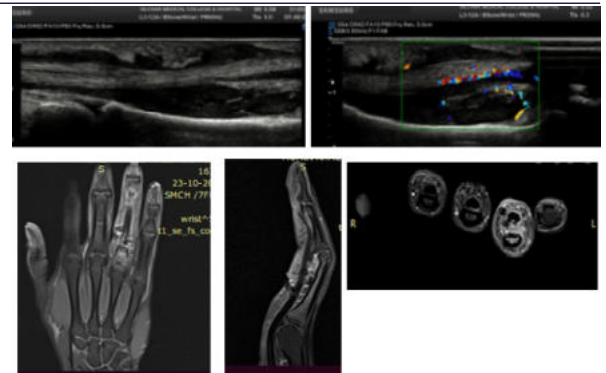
USG images shows synovial thickening, thickened hypoechoic flexor digitorum superficialis and profundus tendons & mild debriginous fluid along tendon sheath and increased vascularity on colour Doppler study. Post contrast T1WI MRI images shows intense enhancement with marked thickening of synovium
